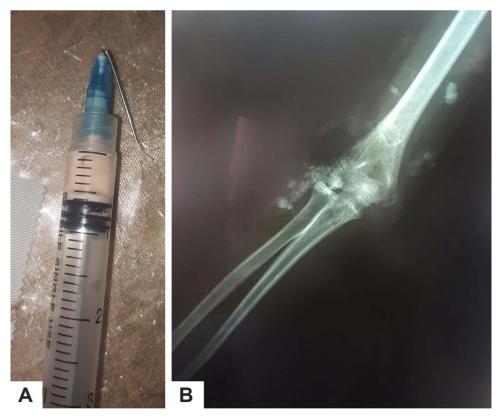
Drained chalky discharge from one of the nodules (A). Plain x-ray demonstrates subcutaneous calcifications around the elbow and brachium (B).
